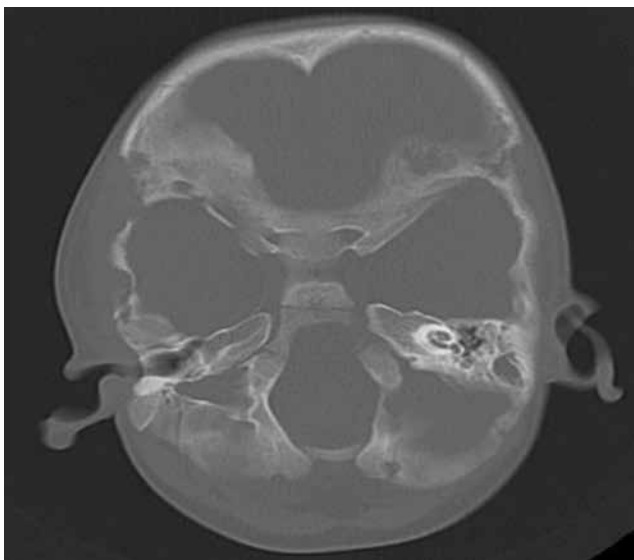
Multiple lytic lesions detected in the cranial bones on computed tomography
